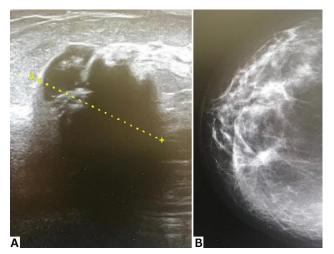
(A) Breast ultrasonography and (B) mammography revealed an irregular, 30 mm hypoechoic area and dystrophic calcifications in the upper-outer quadrant of the right breast
